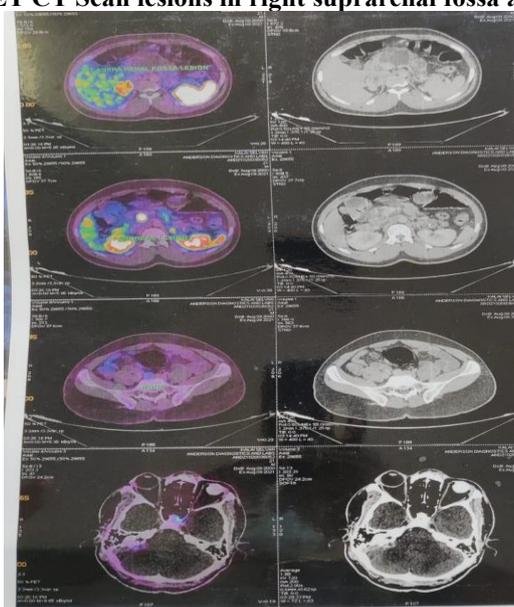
PET CT Scan lesions in right suprarenal fossa and pancreas
